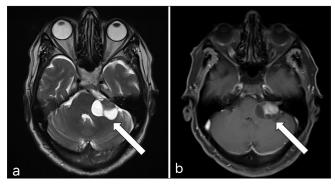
(a) T2-weighted axial magnetic resonance imaging (MRI) image showing a partly solid and partly cystic cerebellopontine angle (CPA) lesion (white arrow) extending to the left internal auditory meatus (IAM) and (b) Contrast-enhanced axial MRI image showing a partly solid and partly cystic CPA lesion (white arrow) extending to the left IAM. The solid component of the lesion is seen enhancing with contrast.
